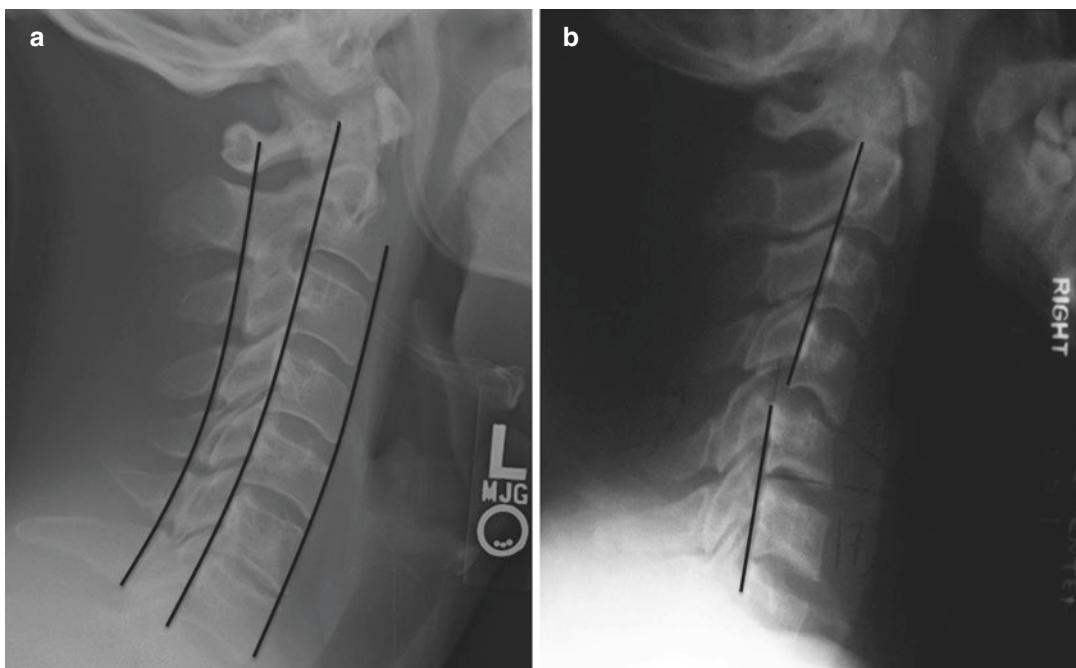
(a) Normal lateral C-spine X-ray showing anterior spinal line, posterior spinal line, and spinolaminar line. (b) C-spine X-ray after trauma.
